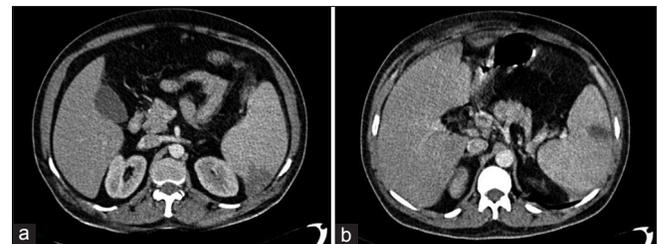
(a) Contrast enhanced computed tomography abdomen: Wedge shaped splenic infarct at the posterior pole. (b) Contrast enhanced computed tomography abdomen: Peripherally located splenic infarct
